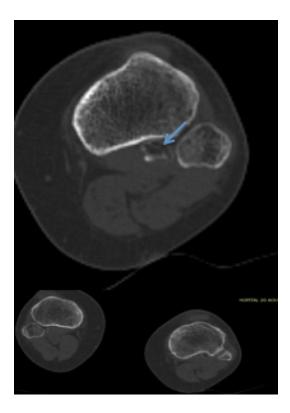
CT scan depicting the cyamella as a rounded osseous body (indicated by an arrow)."
